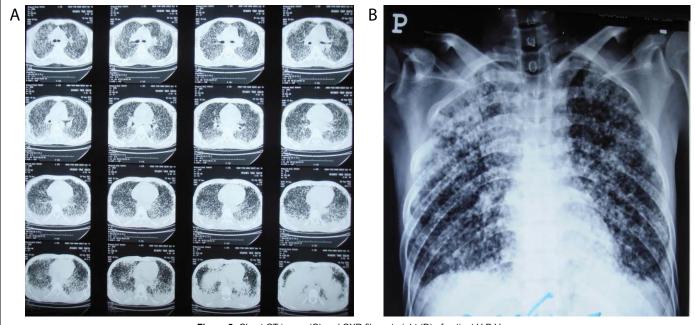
Chest CT image (C) and CXR films straight (D) of patient H.B.V.
